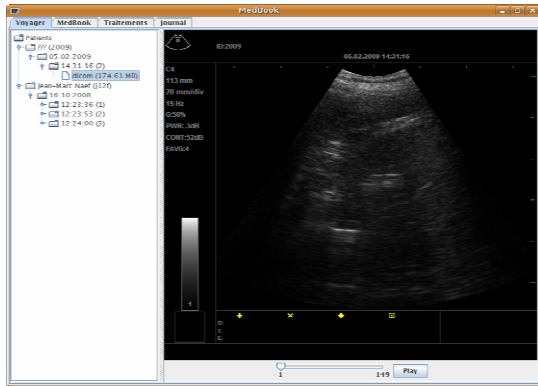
Medbook screenshot: selection, compression and transmission of an ultrasonography video sequence
